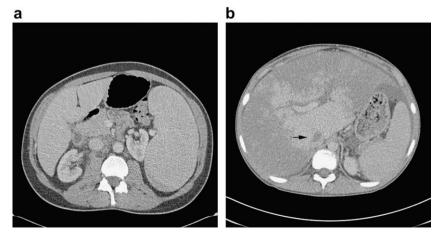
The use of CT in splenomegaly. (a) Contrast-enhanced axial CT image in a patient with hairy cell leukaemia. There is massive splenomegaly with antero-medial displacement of the left kidney. (b) Contrast-enhanced axial CT image in the venous phase. There is poor enhancement of the peripheral liver and a filling defect in the IVC (arrow). Contrast enhancement of the caudate lobe is preserved due to separate, direct drainage into the IVC. This is Budd–Chiari syndrome, one of the few causes of splenomegaly that has diagnostic imaging appearances.
